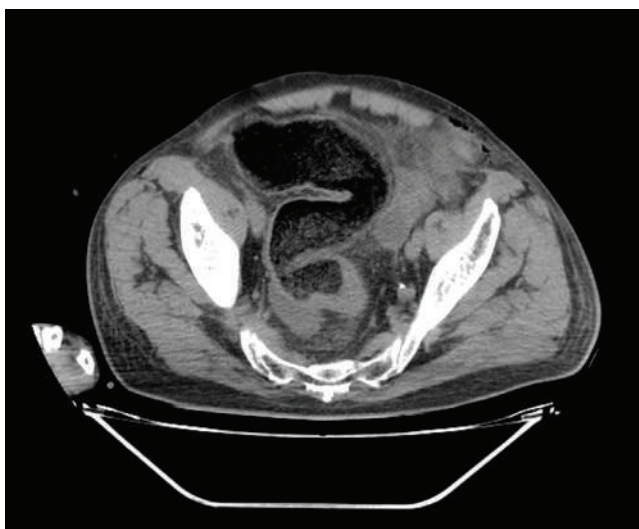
Contrast-enhanced CT scan on the second postoperative day revealed a scirrhous mass at the rectosigmoid junction and dilation proximal to it.
